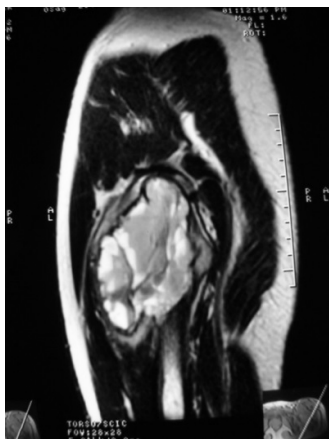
Sagittal T2 weighted MRI of the proximal femur showed multiloculated expansile cystic lesion with fluid and fluid level
